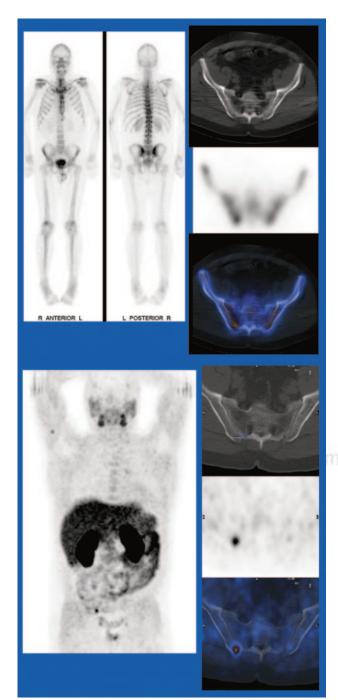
¹⁸F-fluorocholine PET/CT is promising in staging and restaging prostate cancer. Technetium bone scans and SPECT/CT imaging (above) in this patient after treatment for prostate cancer could not demonstrate the osseous metastases that were seen clearly with ¹⁸F-fluorocholine PET/CT (below).
